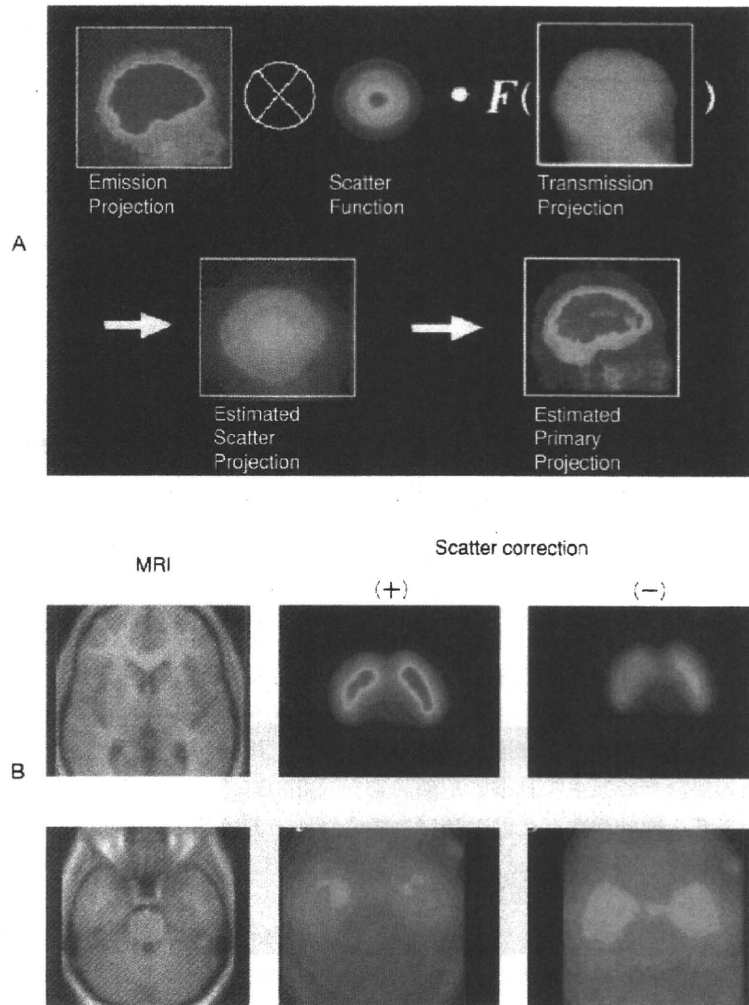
定量的 SPECT 画像再構成における散乱線補正の効果
